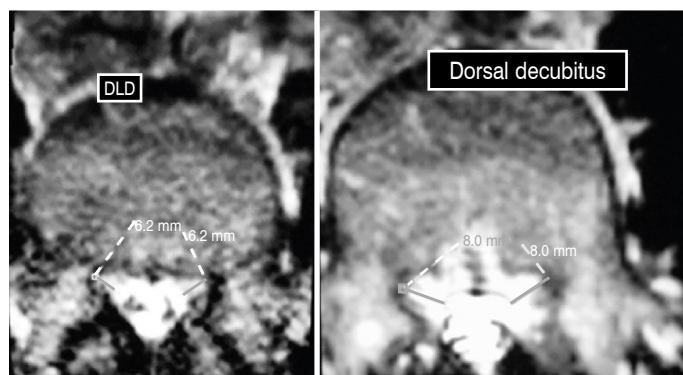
MR image in right lateral decubitus on the left and in right dorsal decubitus on the right, with their respective measurements.
